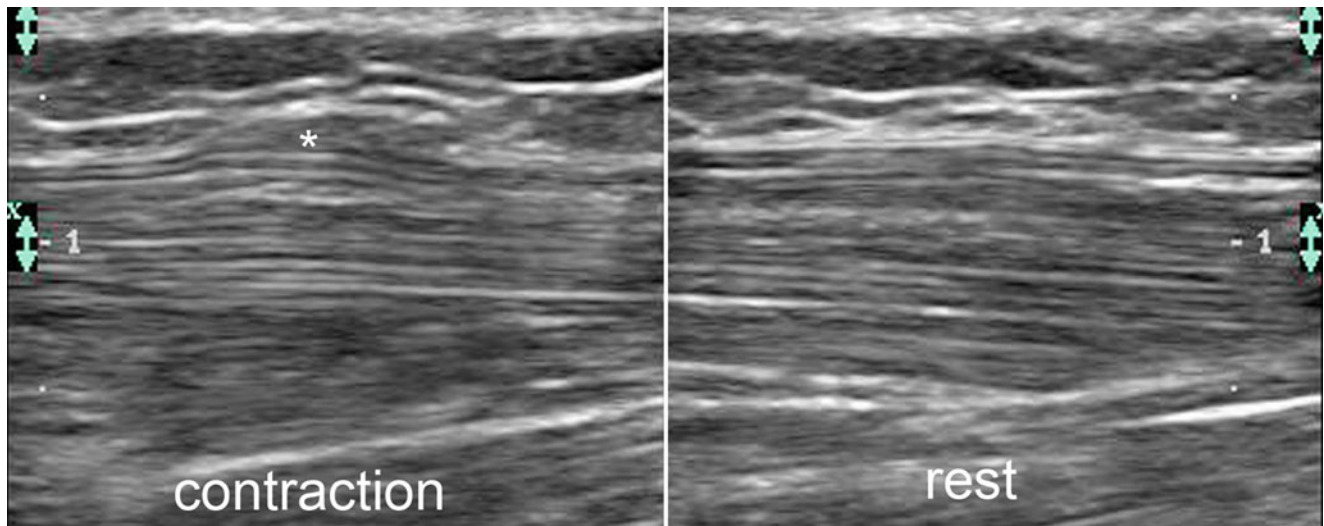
Herniation of the musculotendinous junction. Dynamic grey scale ultrasound image (dynamic study under contraction and rest) shows a focal bulge (*) of the surface of the tibialis anterior musculotendinous junction under contraction
